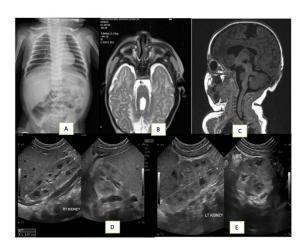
(A) Interstitial infiltrate in the lungs, differential diagnosis: pneumonia. (B) MRI axial slice image supporting a diagnosis of Joubert syndrome, associated with a posterior meningocele in the occipital midline (evident bone defects and the size of the lesions above), along with ventriculomegaly (exvacuo), anti-white matter volume loss, and hypotrophy of the corpus callosum. (C) An MRI sagittal slice showed no obvious cortical malformations, cerebral edema, encephalomalacia, bleeding, calcifications, or current intracranial lesions/masses. (D)(E) Findings suggest bilateral parenchymal kidney disease, predominantly on the left side.
